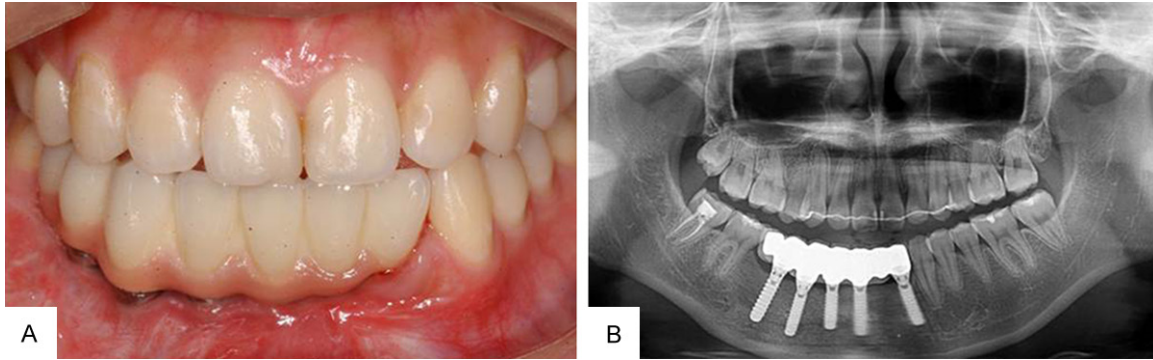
A. One year follow-up after the superstructure was completed. B. One year follow-up after the superstructure was completed, panoramic radiographs revealed bone graft healed well, with good osseointegration. There was no bone resorption around implant.
